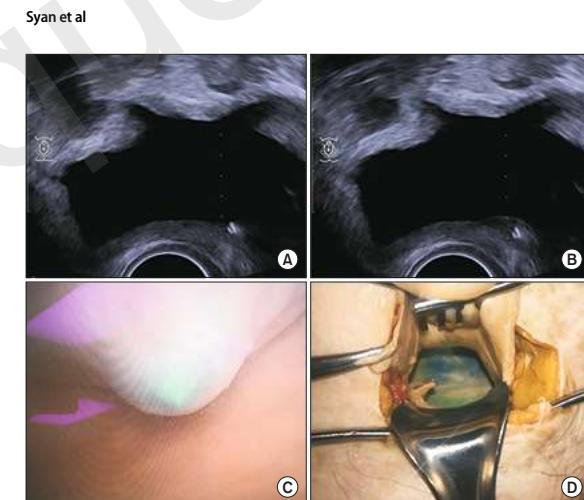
Ultrasound, cystoscopic and gross visualization of the bladder trigone. (A) Ultrasound pre-injection. (B) Ultrasound post-injection. (C) Cystoscopy pre-injection. (D) Cystotomy post-injection.
